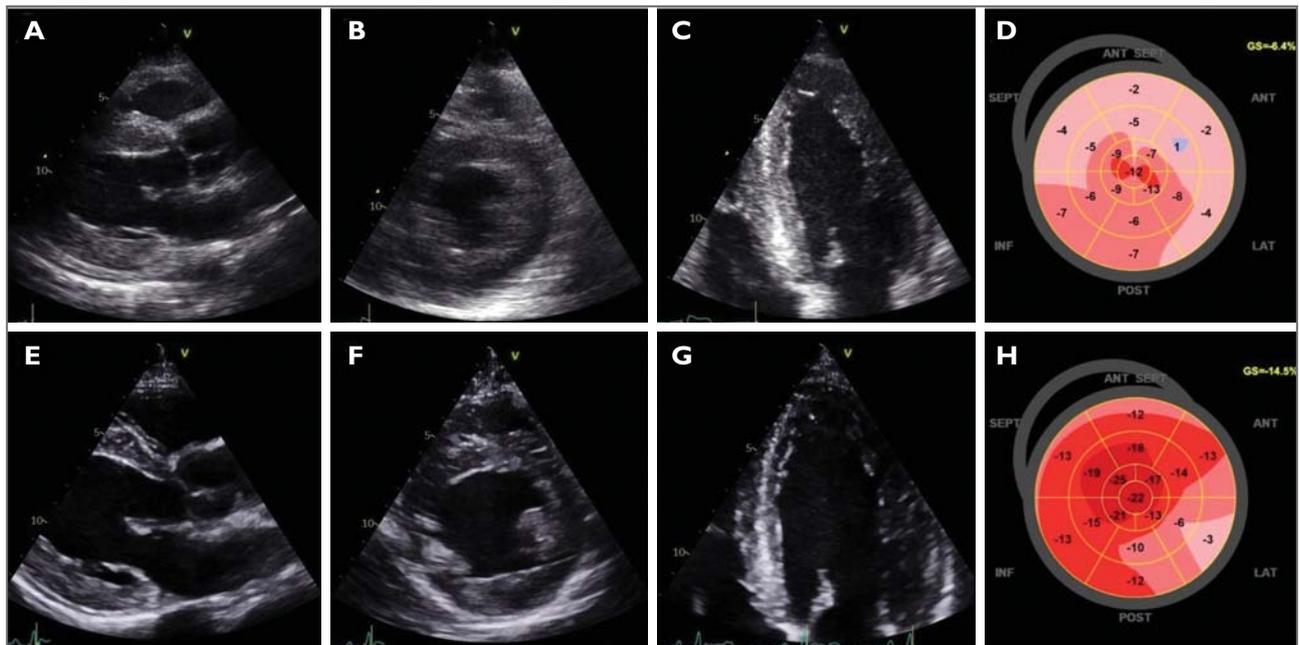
Transthoracic echocardiogram (TTE) of Case 2 performed during initial presentation (top row) and at 1 month follow up (bottom row). (A) to (C) Parasternal long axis (PLAX), short axis (PSAX) and apical 4 chamber (A4C) views showing diffuse left ventricular hypertrophy (pseudohypertrophy) secondary to diffuse myocardial oedema. (D) Speckle tracking showing severely reduced global longitudinal strain of the left ventricle. (E) to (G) Corresponding TTE windows to (A) to (C) performed at 1 month follow up showing significant reduction in left ventricular wall thickness. (H) Repeat speckle tracking at follow up showing significant recovery in global longitudinal strain.
